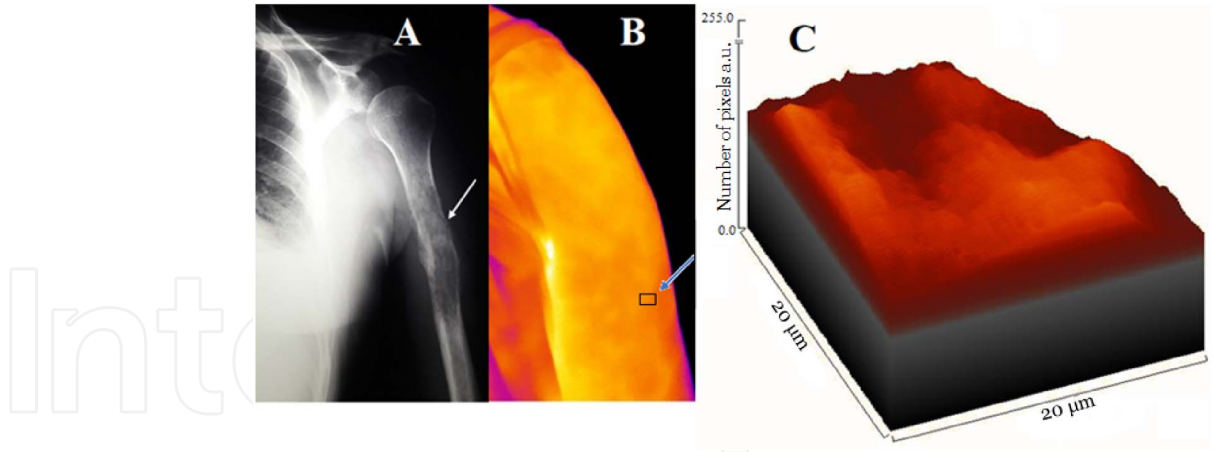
Images of a patient's arm who was diagnosed with metastatic cancer at the humerus using: (A) X-rays, (B) thermographic, and (C) ImageJ analysis at the square cancerous area, as it was detected using thermal camera. The two craters in (C) correspond to increased aggregates, due to cancer development. ((A,B) Dr. Mavrogenis and (C) Dr. Anastassopoulou's personal archive.)
